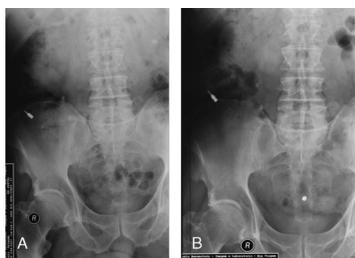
Abdomen radiograph showing little displacement: 7 (A) and 14 (B) days.
